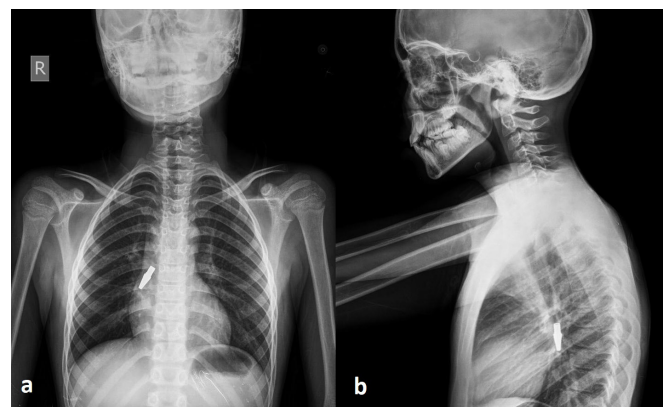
(a) Aspirated pen tip, PA chest x-ray, (b) Aspirated pen tip, lateral chest x-ray.
